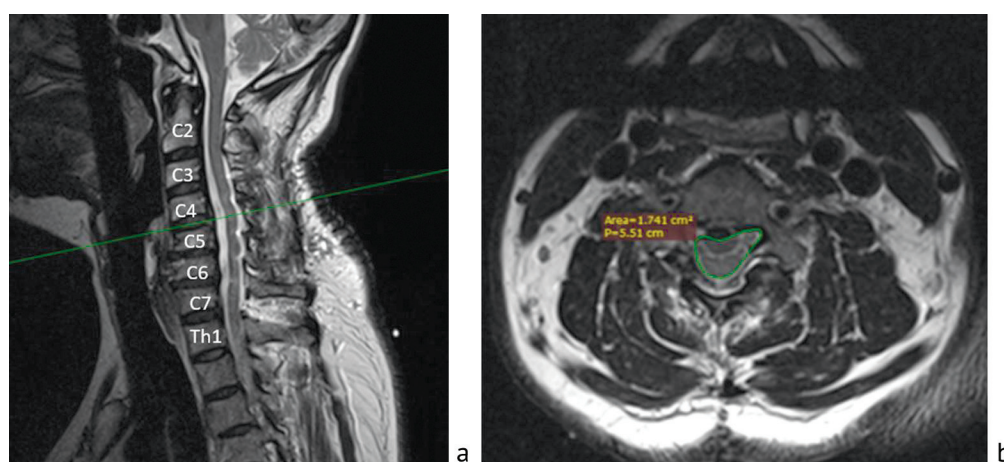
MRI of the patient's cervical spine; condition after laminoplasty at the level of C4-C7; without signs of central stenosis: a sagittal view; b axial view
